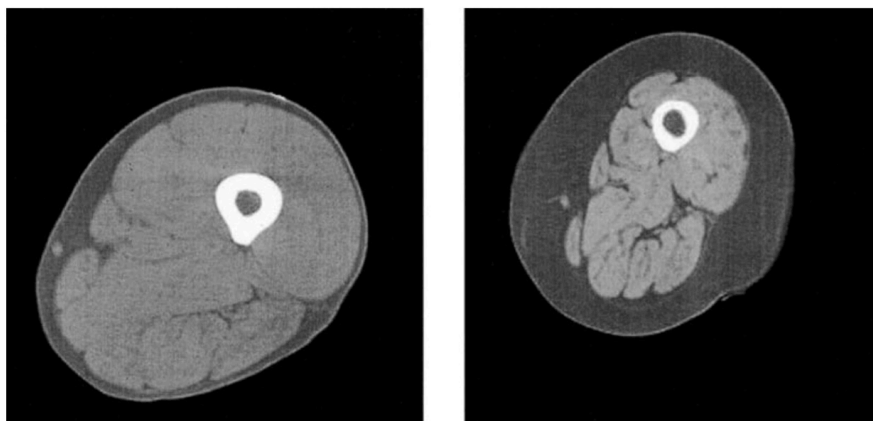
MRI images through the mid-thigh of a 25-year-old healthy adult (left) and a 75-year-old healthy adult (right). Note the smaller muscle mass (light grey), larger subcutaneous fat (dark grey), and increased intramuscular fat (dark grey lines) in the older adults upper leg (reproduced from Roubenoff (320) with permission from Oxford University Press).
